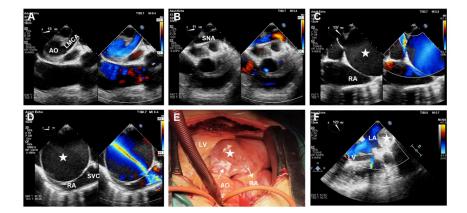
Intraoperative TEE and surgical images. (A) Pre-TEE shows an aneurysmal dilation of left main coronary artery (LMCA) origin. (B) Color Doppler imaging with systolic aliased flow in the sinus node artery (SNA). (C-D) Pre-TEE bicaval view reveals an aneurysm-like fistula from left main coronary to right atrium (RA), which adjacent to superior vena cava (SVC). (E) A collapsed left coronary aneurysm under cardiopulmonary bypass. (F) Post-TEE long-axis view reveals a collapsed aneurysm in the posterior of the left atrium. White star represents aneurysm.
